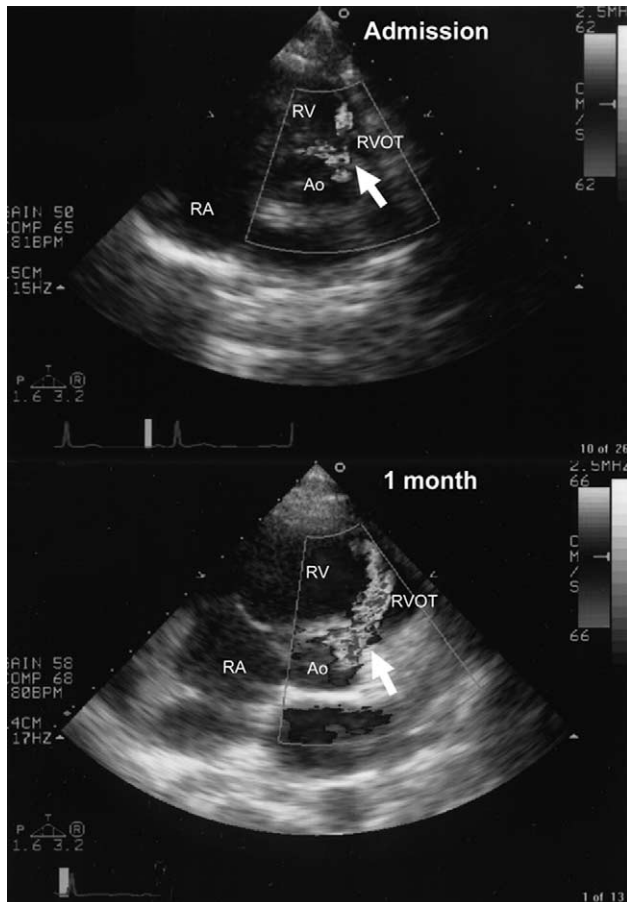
Parasternal short axis view showing increased left to right shunt (arrow) after 1 month. (Ao = aorta; RA = right atrium; RV = right ventricle; RVOT = right ventricular outflow tract.)
